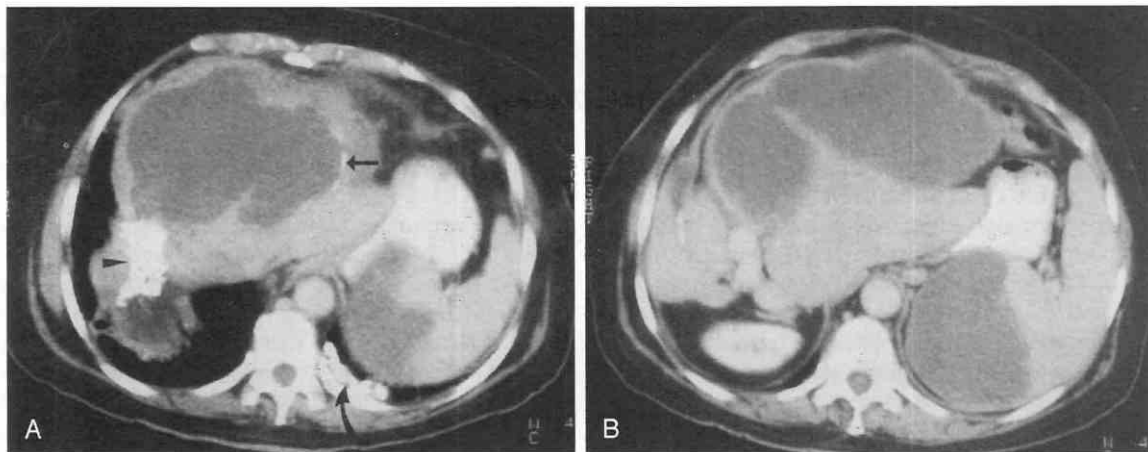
The patient is a 77-year-old woman with echinococcal cysts of the liver and spleen. *A*, Contrast-enhanced CT scan shows a large cyst of the liver with calcification of the cyst wall (*straight arrow*). An area of dense calcification (*arrowhead*) is related to a previous resection. Involvement of the spleen is present. Calcification in the left lung base (*curved arrow*) is related to prior involvement of the pleural space. *B*, Several centimeters more caudal to *A*, additional cysts involving the liver as well as the large splenic cyst are shown.
